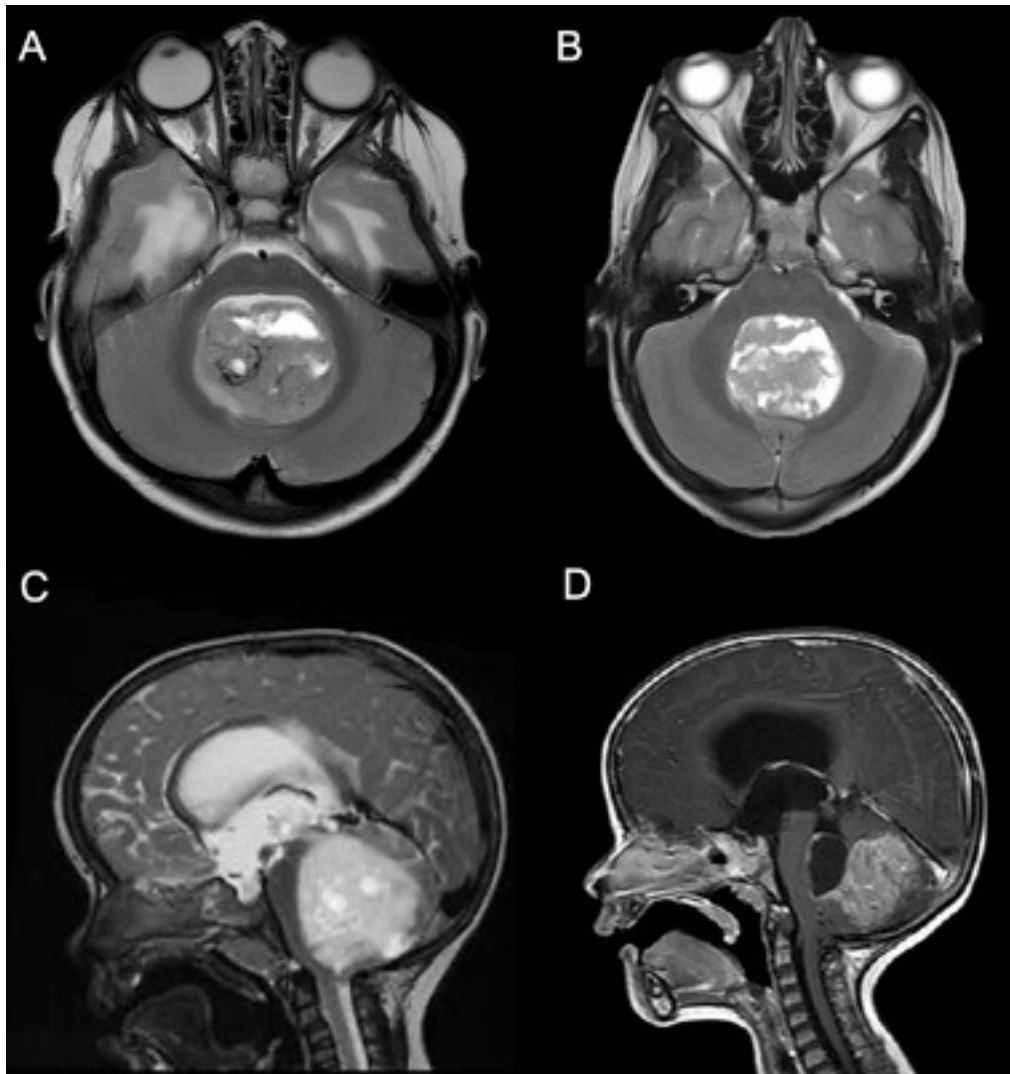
A series of FLAIR scans depicting different posterior fossa tumors in pediatric case studies. A. Axial view in a case that yielded cerebellar mutism following resection (reproduced with permissions from “The Posterior Fossa Society”); B. Axial view in a 16 year old female, presenting with binocularly blurred vision and emotional changes such as “giddiness” (Shah, 2012); C. Sagittal view in a 5-year-old male presenting with cerebellar symptoms (AlMatter). D. Sagittal view of medulloblastoma in a 2-year old female presenting with ataxia, lethargy, and post-operative cerebellar mutism (Gadgil, Hansen, Barry, Chang, & Lam, 2016). Images used with permission of authors. Note that images B-C are reproduced for publication in compliance with Creative Commons licenses.
